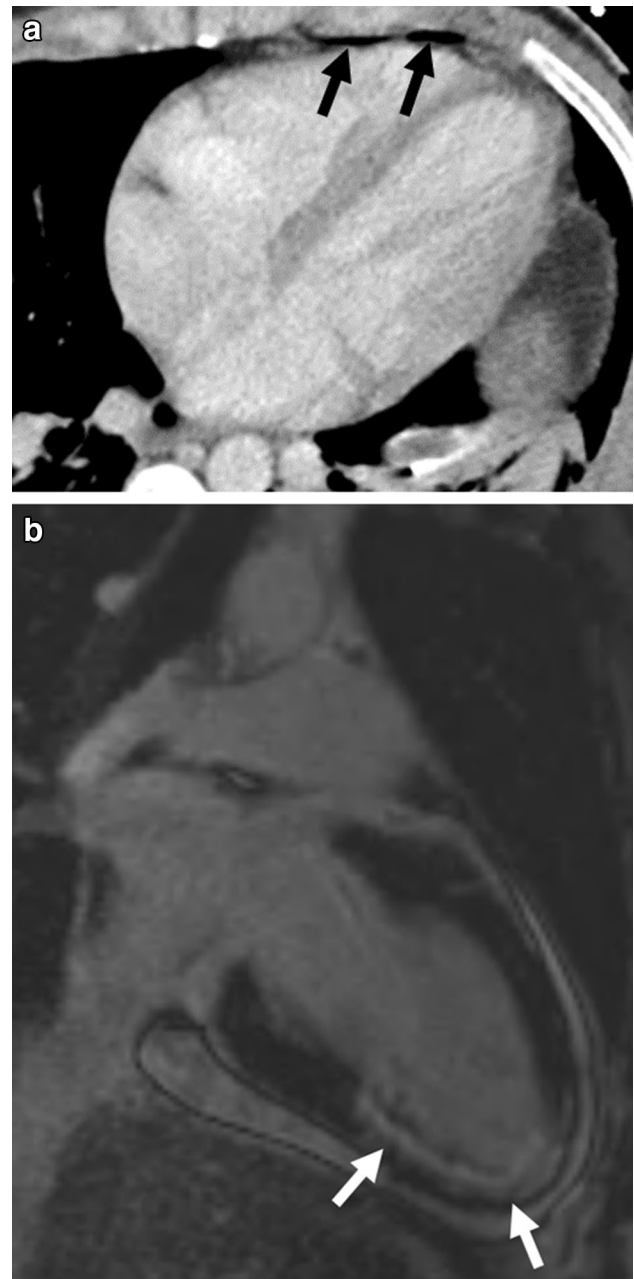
a, b 28-year-old man involved in an MVC. Axial MDCT image with contrast (a) demonstrates pneumopericardium (black arrow), but no direct signs of cardiac injury. At presentation, the patient had elevated troponins and a right coronary artery injury was confirmed on catheter angiography (images not included). A follow-up cardiac MRI was performed with 2-chamber long axis delayed post-contrast phase sensitive inversion recovery image showing subendocardial and transmural delayed contrast enhancement of the inferior septal wall near mid ventricle and apex (white arrow) consistent with a resultant myocardial infarct in the right coronary artery territory
